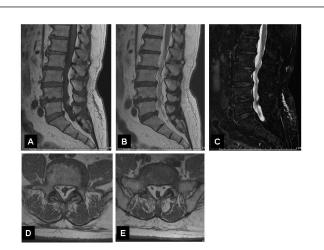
MRI showing increased epidural fat tissue, iso signal intensity to the subcutaneous fat. A: Sagittal T1-weighted images. B: Sagittal T2-weighted images. C: Sagittal fat suppressed T2-weighted images showing suppression of the fat signal. D: Axial T1-weighted images at the level of the upper edge of the L5 vertebral body. E: Axial T1-weighted images at the level of the upper edge of the S1
